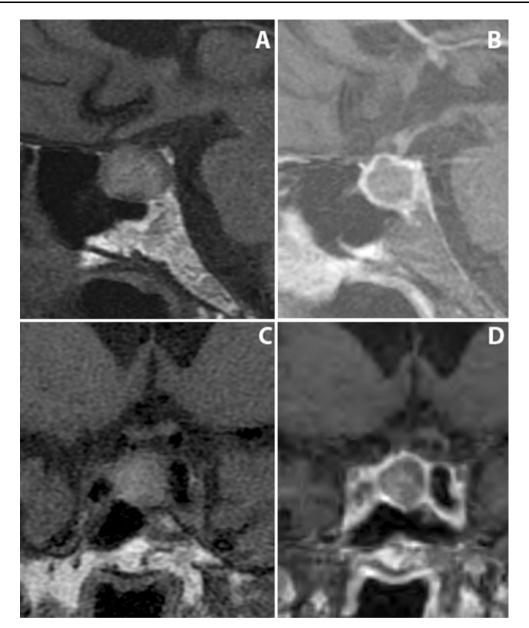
MRI of patient's pituitary. a The T1-weighted sagittal image pre-contrast identified a 1.4-cm pituitary macroadenoma. b The sagittal image post-contrast was notable for peripheral enhancement of the pituitary, without central enhancement. c The coronal image
